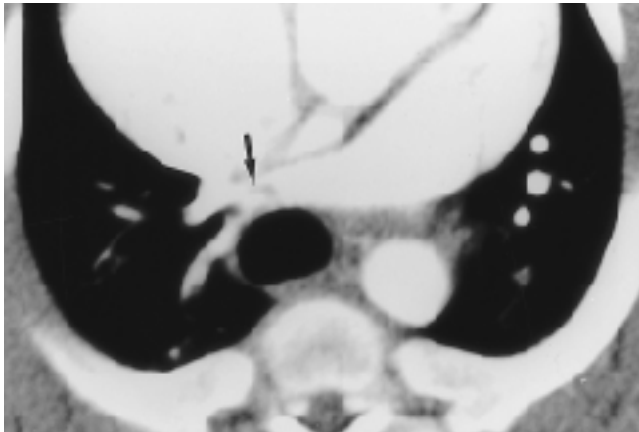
Missed embolus due to abutting the wall of pulmonary artery on spiral CT. Contrast-enhanced spiral CT scan obtained after induction of pulmonary embolism shows a linear filling defect (arrow) in right pulmonary artery.
